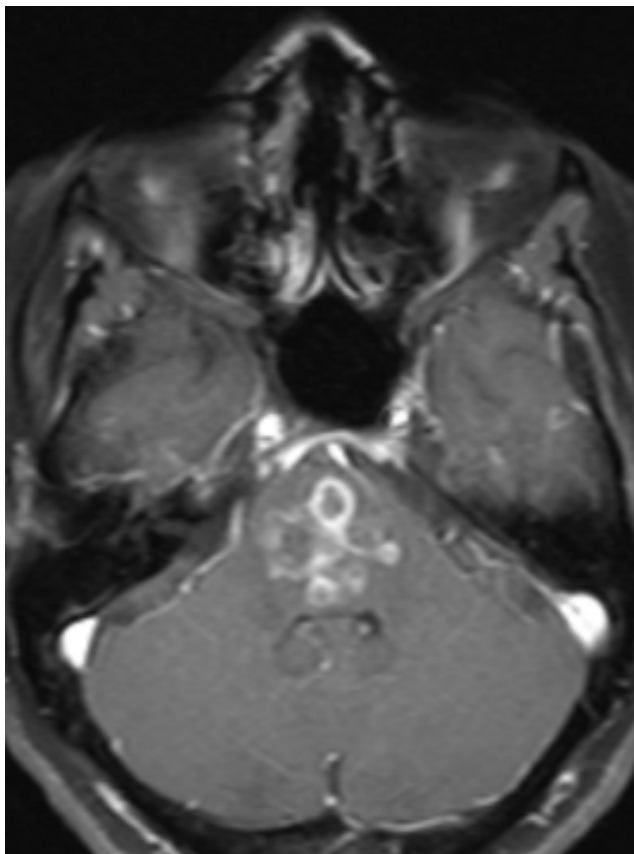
MRI Brain, Axial T1 Weighted post gadolinium contrast sequence, 6 weeks after initiation of treatment, showing mild reduction in size of lesion.
